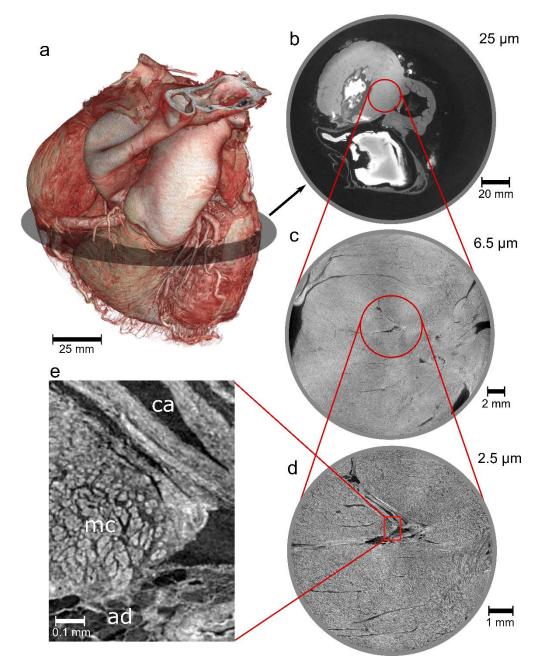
HiP-CT images of an intact human heart. a, 3D view of the human heart imaged using the beamline BM05 at
